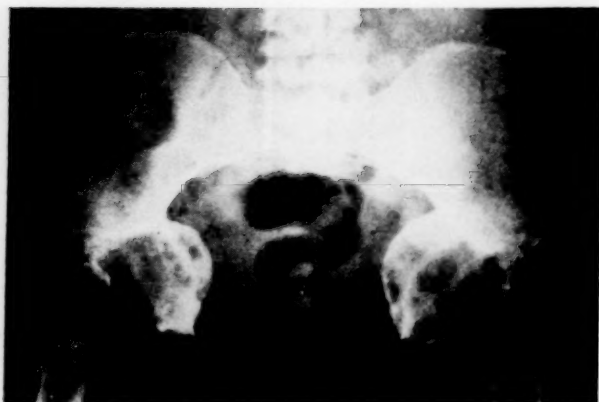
Anteroposterior roentgenogram of the pelvis showing destruction of femoral heads and acetabular protrusions (protrusio acetabuli or Otto pelvis).
